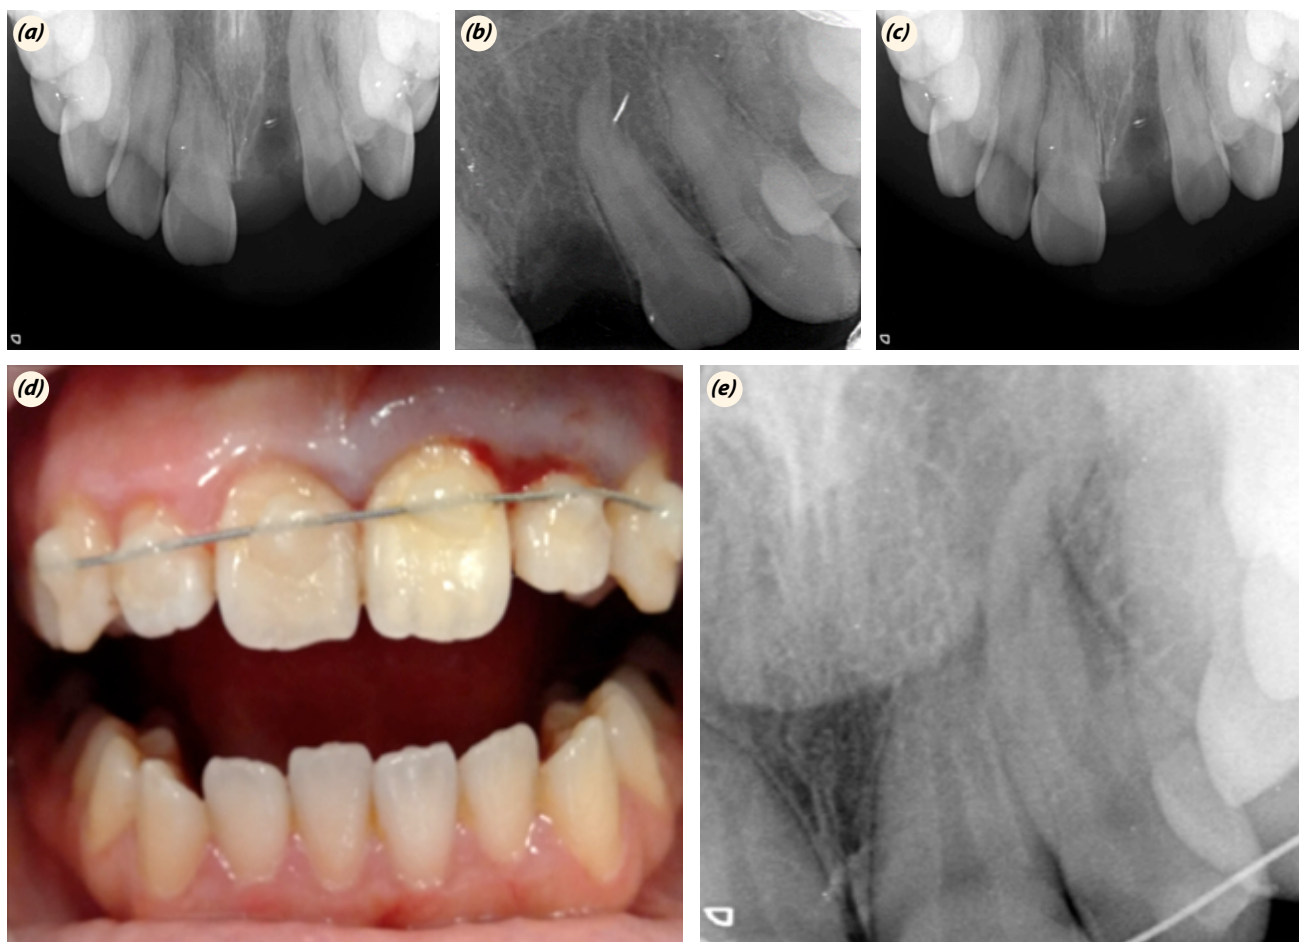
Intraoral image taken after the accident in our clinic (a). Occlusal and periapical radiograph taken after 48 h of the accident: avulsed maxillary left incisor and intruded maxillary left lateral incisor (b, c). Periapical radiograph and clinical view of maxillary left incisors (d, e).
